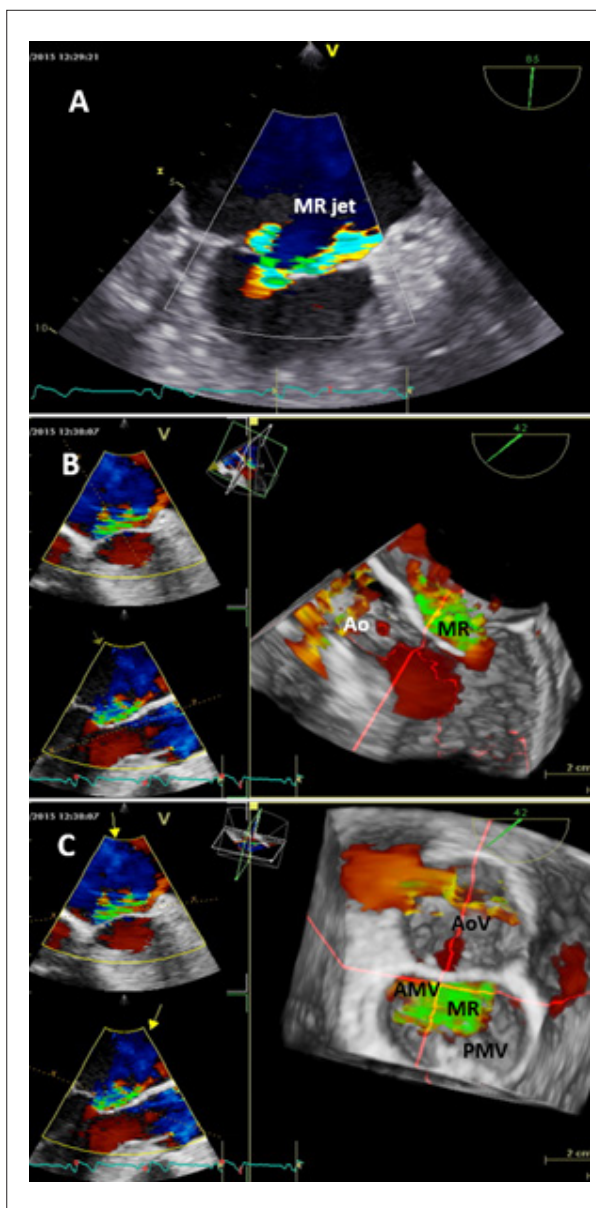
Two- and three-dimensional color assessment of the mitral regurgitation (transesophageal approach). Panel A. The mitral valve, visualized at 85 degrees, shows the two components of the mitral regurgitation, caused by the prolapse and the pseudo-cleft. Panel B. Long-axis view throughout the A2/P2 scallops shows the mitral regurgitation jet caused by the prolapse of P2, opposite the scallop. Panel C. The "surgical view" of the mitral valve shows the wide origin of the mitral regurgitation jet, seen from the left atrium, which is directed anteriorly (only retrograde flows are displayed). AMV: anterior mitral valve, Ao: aorta, AoV: aortic valve, MR: mitral regurgitation, PMV: posterior mitral valve.
